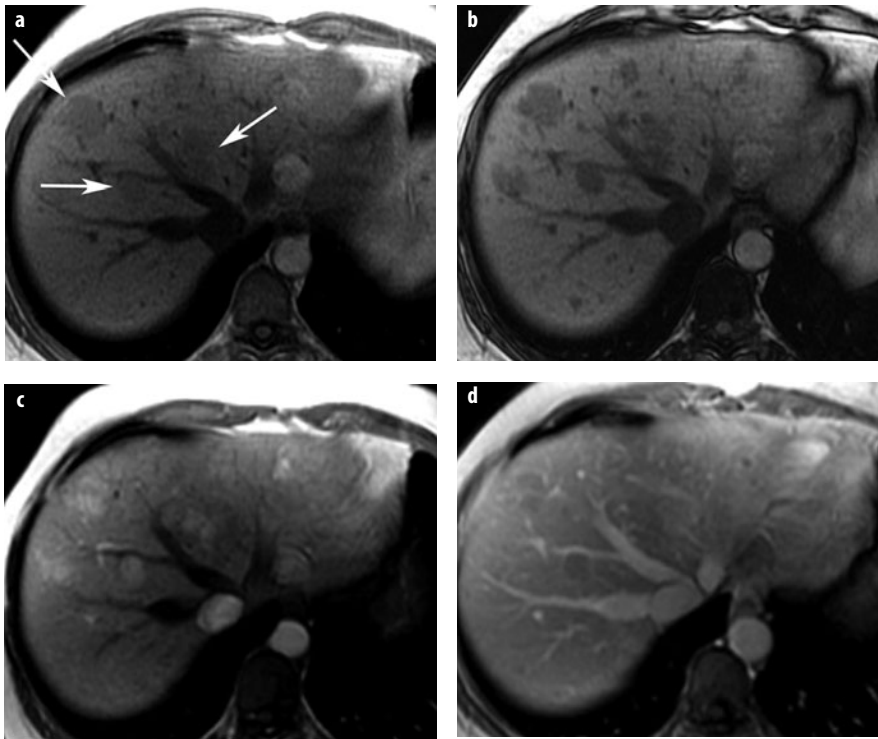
a-d. HCA in adenomatosis. Human plasma fibronectin (HNF)-1 α -mutated type. a, b T1-weighted GRE images: a in-phase image shows several mildly hypointense lesions in the right lobe (*arrows*), which show considerable signal intensity drop on the b opposed-phase image due to intratumoral fat. c, d After contrast, lesions are hypervascular in the c arterial-phase image, with washout in the d venous phase
